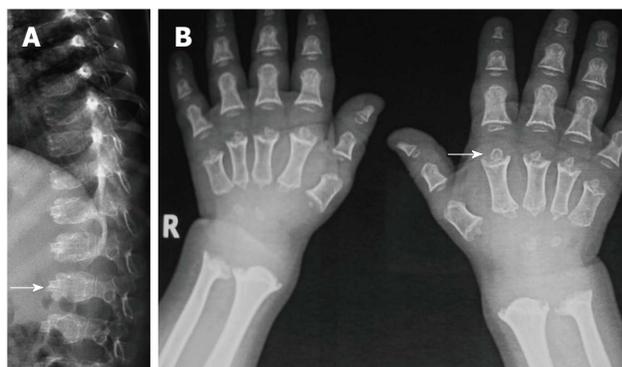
Pseudoachondroplasia. Lateral radiograph of spine shows typical central anterior tongue (arrow, A) in lumbar vertebrae. Radiograph of both hands (B) also show multiple abnormalities of epiphyses of metacarpals and phalanges with secondary metaphyseal widening (arrow).
